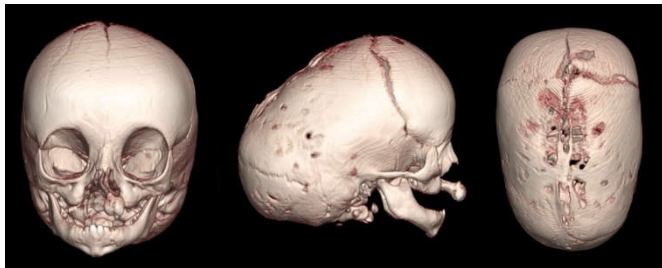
CT study at 7 months of age. Imaging reveals scaphocephaly with a fused sagittal suture
